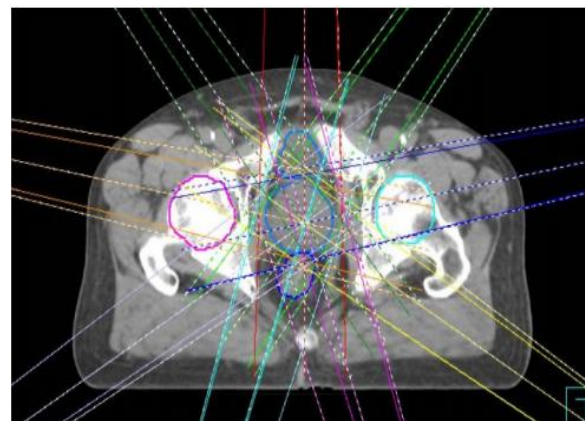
Beam arrangement on Planning CT
